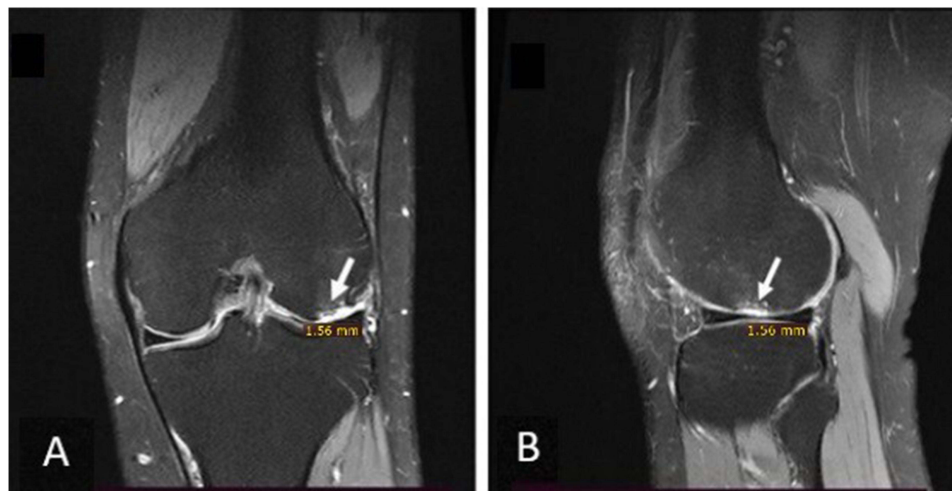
MRI images of patient with Grade 2 osteoarthritis. Preoperative MRI imaging revealed a chondral defect (arrow) on the lateral femoral condyle (A and B). The thickness of the cartilage is 1.05 mm.
